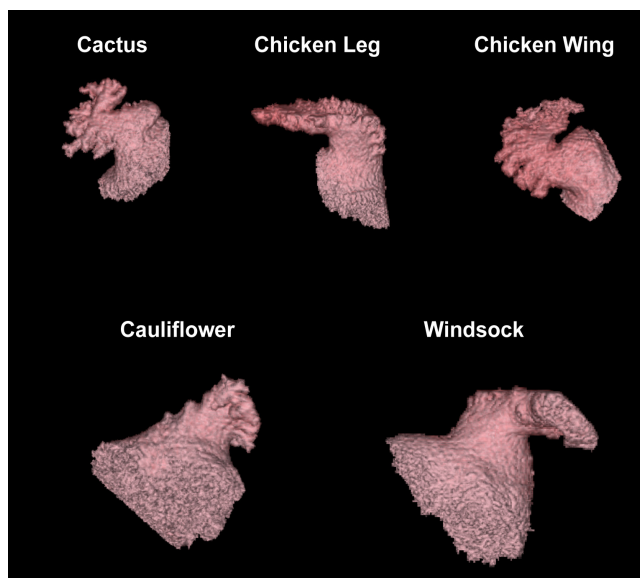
Different shapes of the left atrial appendage as assessed by cardiac CT imaging.
